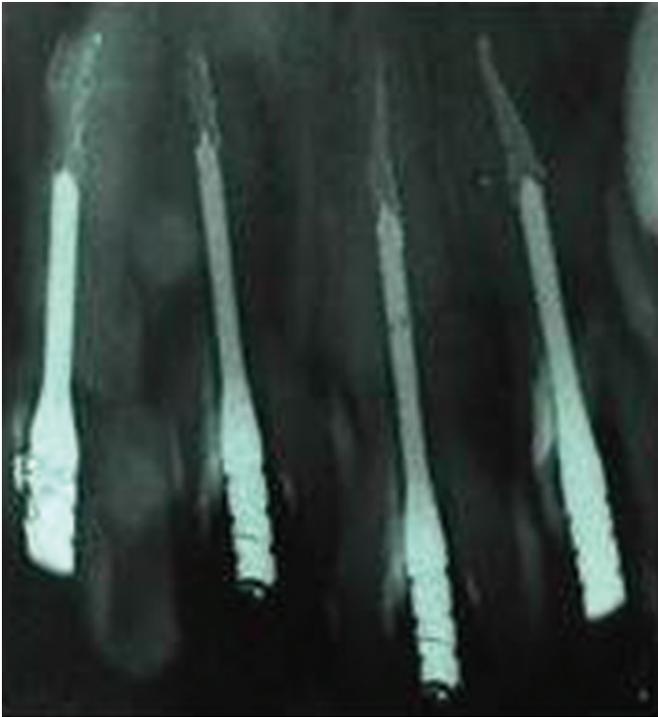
Intraoral periapical with i-post
